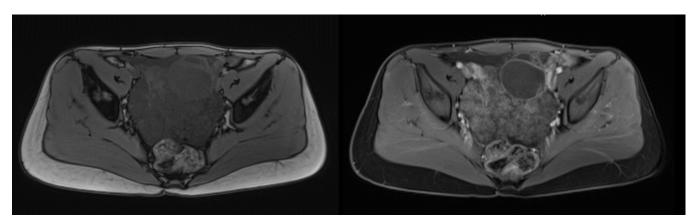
Axial T1-weighted MR image (left) and axial contrast enhanced T1-weighted MR image (right) shows large pelvi-abdominal multilocular complex cystic lesion.
